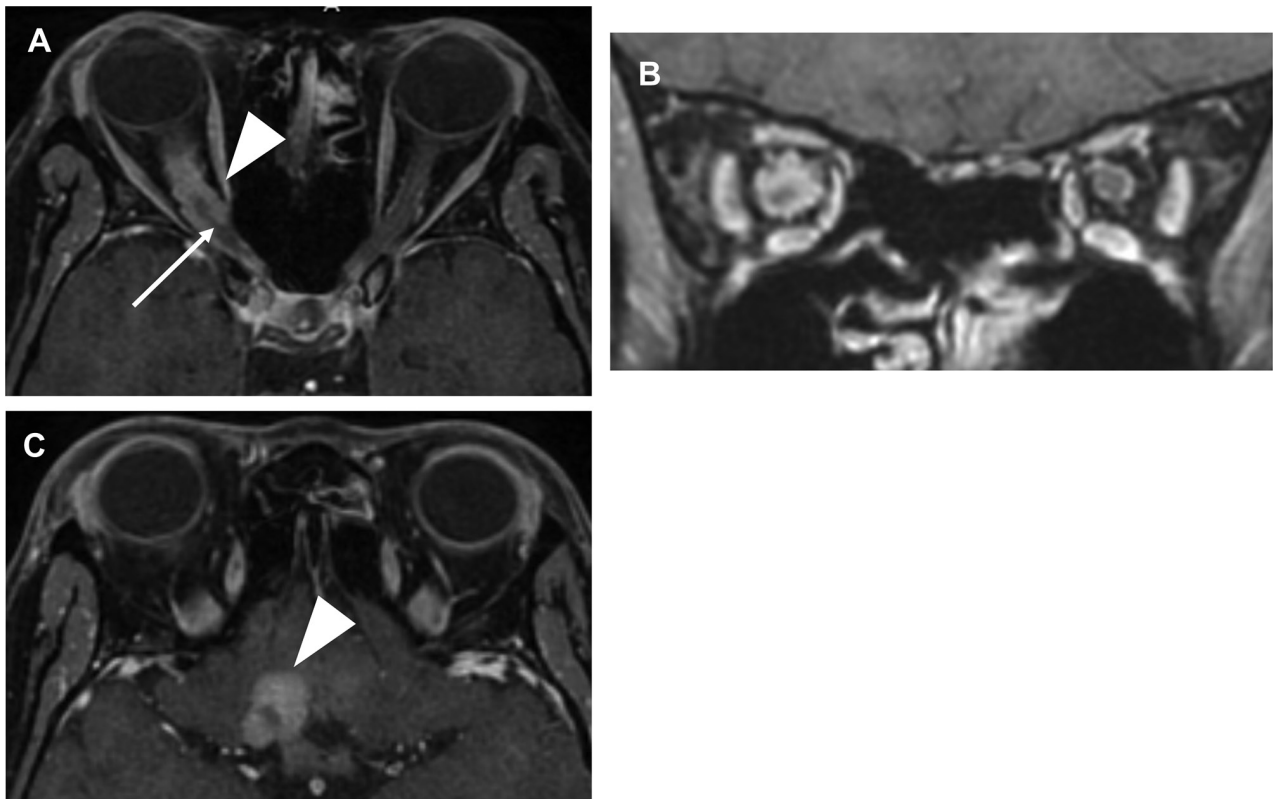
(A) Contrast-enhanced MRI showing thin right optic nerve (arrow) and ONSM encasing the right optic nerve (arrowhead). (B) MRI showing homogeneous enhancement with a 'tram-track sign' around the non-enhancing right optic nerve. (C) ONSM extends to the right carotid artery, close to the optic chiasm (arrowhead indicates meningioma). MRI, magnetic resonance imaging; ONSM, optic nerve sheath meningioma.
